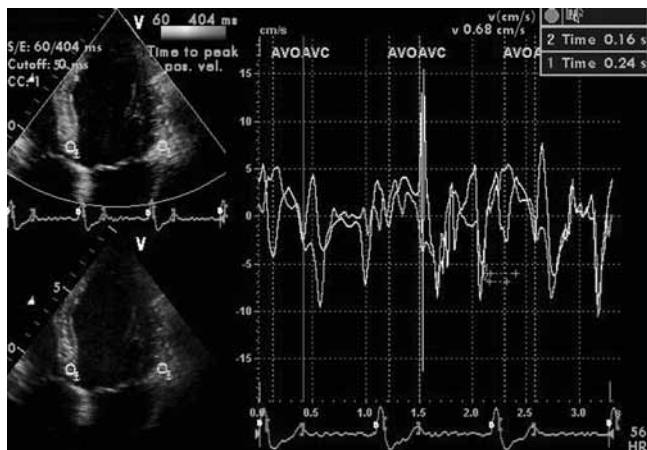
Time-to-peak systolic velocity measurement in the left ventricular septal basal and lateral basal segments by tissue Doppler imaging under guidance of tissue synchronization imaging in a dilated cardiomyopathy patient with left bundle branch block
